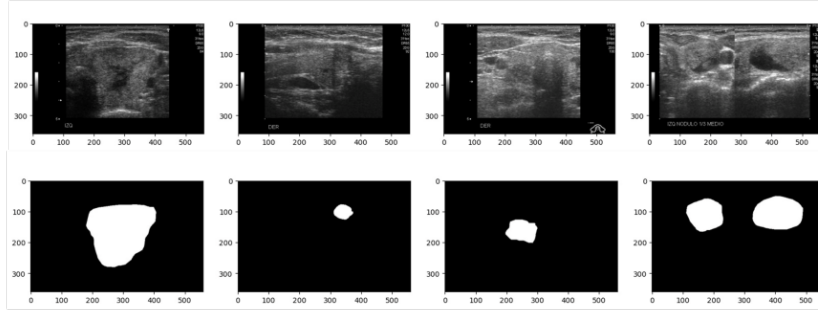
Samples of ultrasound thyroid data and its masks.
